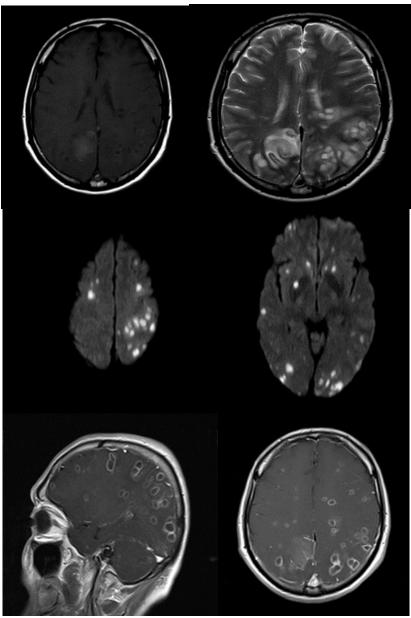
Multiple T1 isointense and T2-FLAIR hyperintense lesions with peripheral edema, some lesions in the bilateral cerebral hemispheres, and the right basal ganglia showed restriction at DWI. The signal change was seen at the right occipital lobe, indicating a peripheral restriction in favor of cerebritis. Post-contrast images showed the pattern of ring enhancement.
